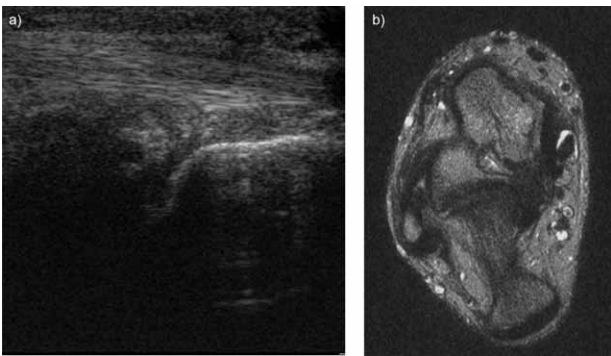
a) (Ultrasound) Stretching (Lesion G1) of the left Anterior tibial muscle tendon; 2.b) (Magnetic resonance). Stretching (Lesion G1) of the right Anterior tibial muscle tendon.
